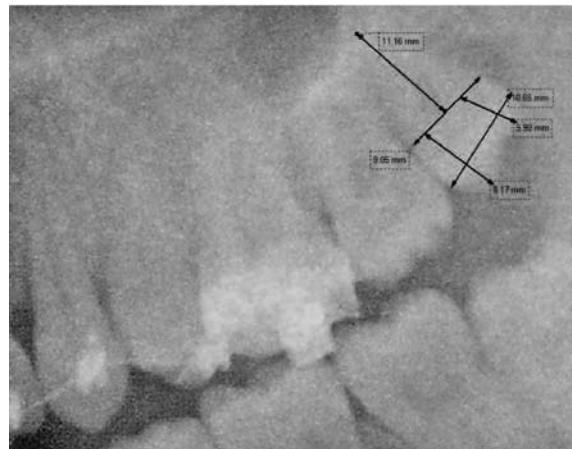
Measurement of height and mesial-distal dimension of the crown, as well as the root length of ITMT in an orthopantomographic image
